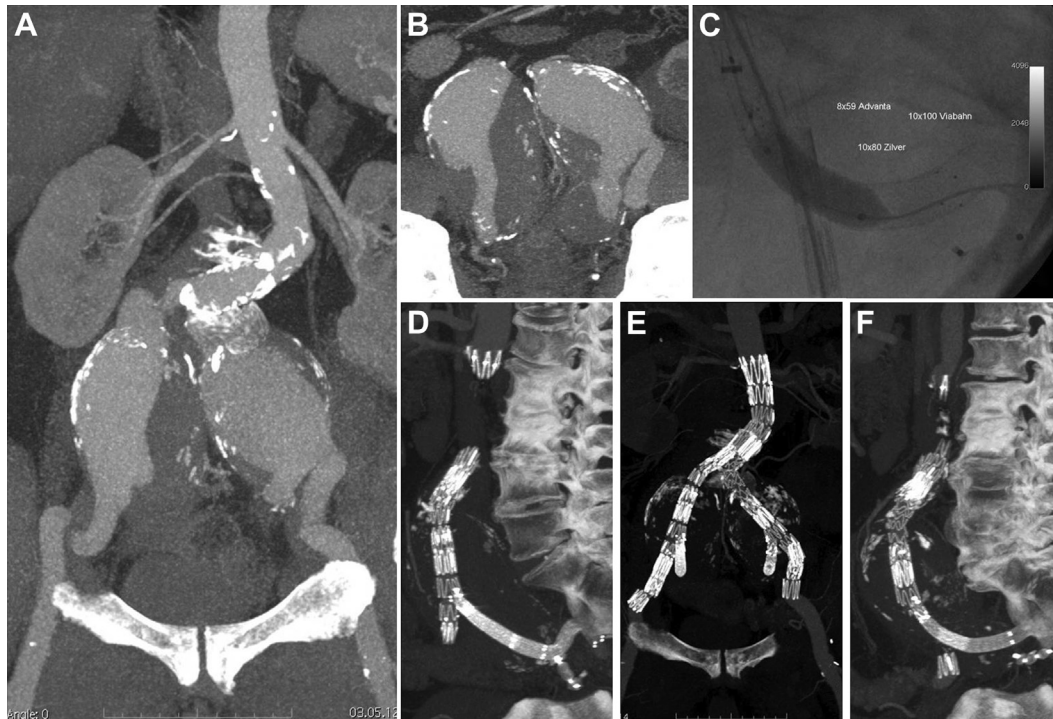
Pre-, intra-, and postoperative demonstration of the technique of endovascular repair of aneurysmal internal iliac arteries (AIIAs) using iliac branch devices (IBDs). A and B, Preoperative computed tomography (CT) angiographic reconstruction of a patient with bilateral iliac and internal iliac aneurysms of more than 5 cm. C, Intraoperative angiography of the technique of endovascular repair AIIAs using IBDs. Please note the sequence of the deployed stents. First, deployment of the V12 iCast/Advanta (Atrium) balloon-expandable covered stent (BECS) in the proximal part of the internal iliac artery. Second, deployment of the self-expanding covered stent (SECS) (Viabahn; Gore). Finally, deployment of the self-expanding bare metal stent (Zilver; Cook). D-F, Postoperative CT angiography with a coronary, axial, and sagittal view.
